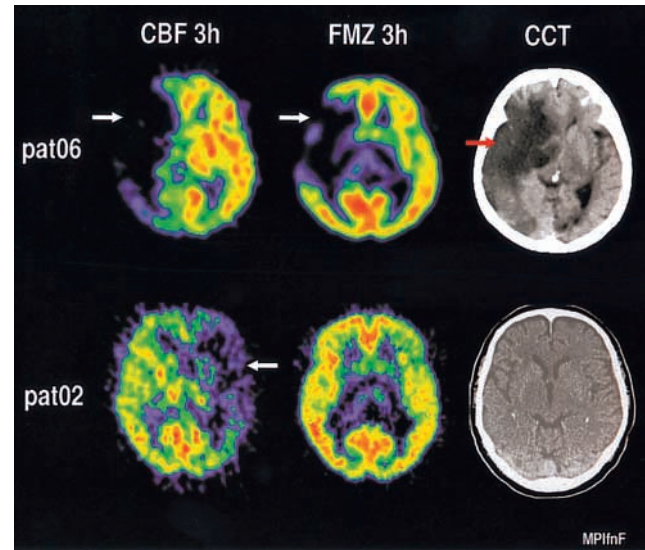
Effect of rtPA treatment in two patients with large ischemic areas (white arrows): patient 6 (pat06) with area of decreased FMZ binding (blue arrow) and corresponding large infarction on late cranial CT (red arrow), and patient 2 (pat02) with no defect in FMZ binding and no infarcted cortex on late cranial CT.
